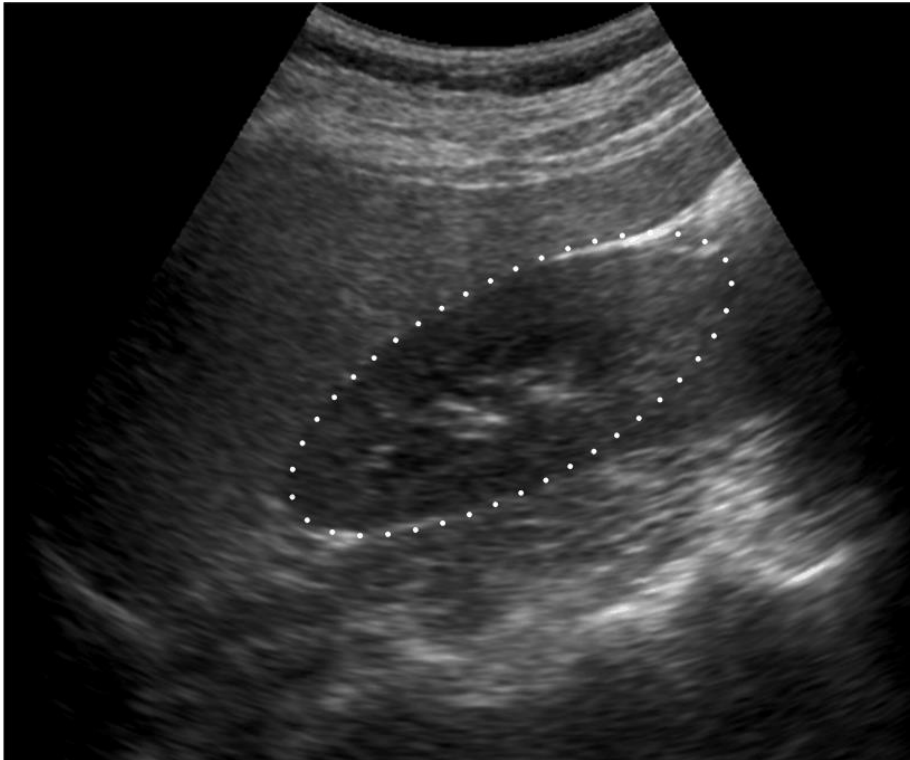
B-mode ultrasound image of normal kidney. The dotted ellipse marks the boundary of the kidney
